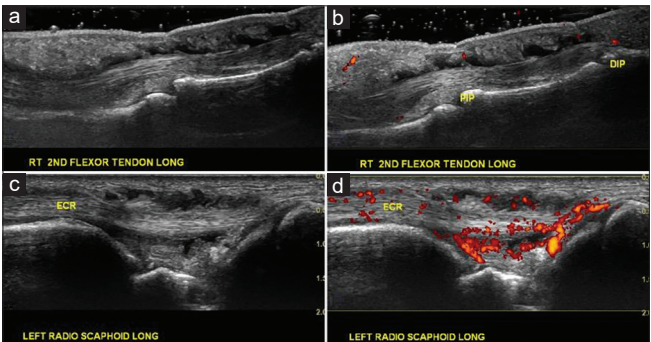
(a) (Gray scale) and (b) (Doppler signal) were right 2nd flexor rheumatoid tenosynovitis, as Grade 1 by EULAR-OMERACT Doppler score; (c) (Gray scale) and (d) (Doppler signal) were rheumatoid tenosynovitis of left ECR tendon as Grade 3 by EULAR-OMERACT Doppler score. EULAR: European League against Rheumatism and ECR: Extensor carpi radialis
